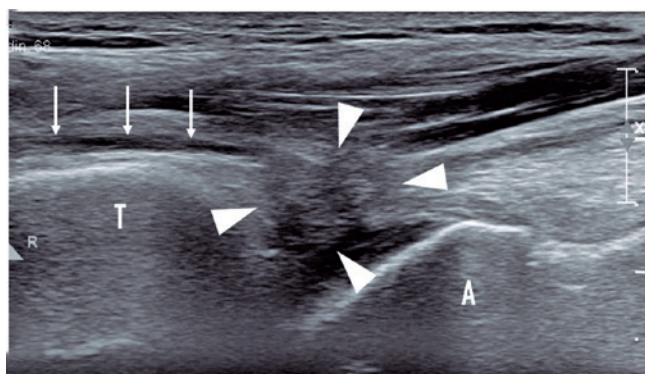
Ultrasonography showing an entrapment of the deep peroneal nerve within postoperative tissue adhesions of the capsule joint. White arrows mark the course of the deep peroneal nerve in longitudinal plane. White arrowheads show the margins of the area of periarticular fibrosis that entraps the nerve in its course.
